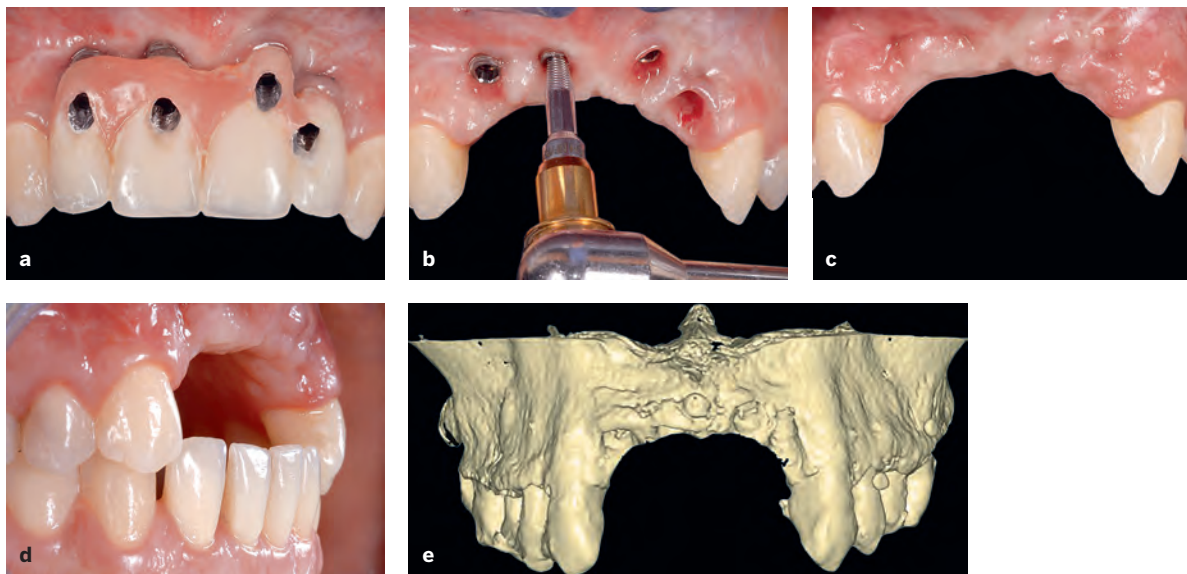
Case 6. (a and b) Clinical view of a compromised anterior maxilla with an unesthetic implant prosthesis treated with four malpositioned implants. Note the close proximity and deep placements of the implants, resulting in inflammation, bleeding, and painful peri-implant mucosa. The implants were removed atraumatically with an implant removal tool and reverse torque. (c and d) Buccal and lateral views of the healed ridge 2 months after implant placement. Note the healthy soft tissue coverage but severe atrophy of the anterior maxilla in the horizontal and vertical dimensions. (e) CBCT buccal view of the severe loss of hard tissue in the anterior maxilla. →
